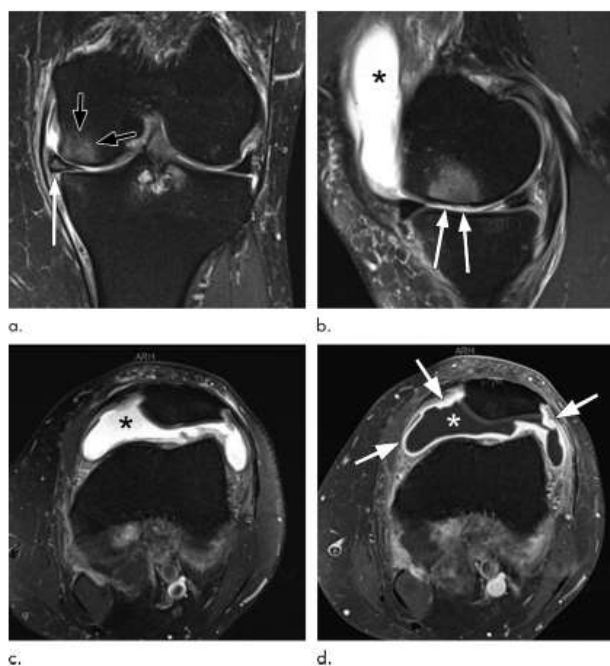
Contrast-enhanced knee MRI in a 71-year-old woman with osteoarthritis (OA). (a) Coronal fat-suppressed intermediate-weighted image showing a signal resembling bone marrow edema (black arrow) and meniscal extrusion (white arrow). (b) Sagittal fat-suppressed intermediate-weighted image confirming femoral cartilage thinning (arrow) and demonstrating an intraarticular joint effusion. (c) Axial fat-suppressed intermediate-weighted image showing a joint effusion with high signal intensity within the synovial cavity. (d) Fat-suppressed T1-weighted image following intravenous contrast administration revealing a thickened, high-intensity synovial lining (arrow), while the joint fluid
